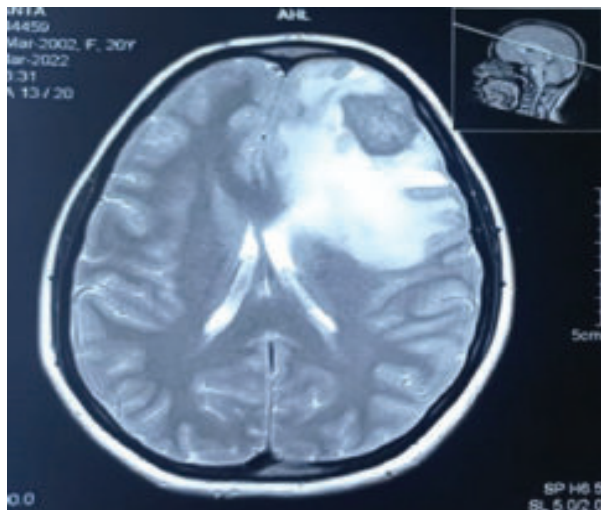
T2 weighted axial plane MRI shows the lesion is isointense. There are no major flow voids within or around the lesion. massive perilesional edema with mass effects
